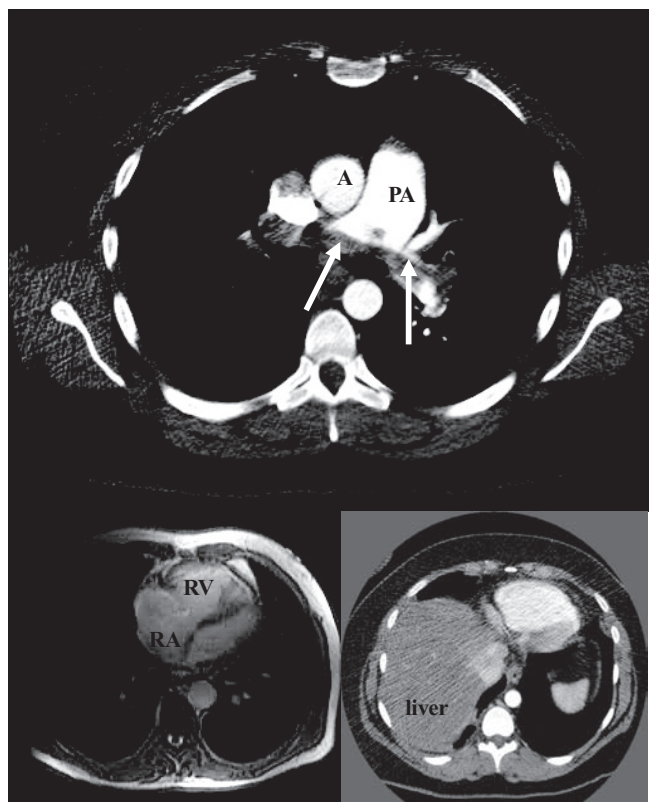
Computed tomography (CT) pulmonary angiography (CTPA) showing a saddle embolus extending into the right and left pulmonary arteries (white arrows). The secondary effects of PE are also shown including dilatation of the main pulmonary artery (PA) compared to the aorta (A), a dilated right atrium (RA) and right ventricle (RV), and evidence of tricuspid regurgitation.
